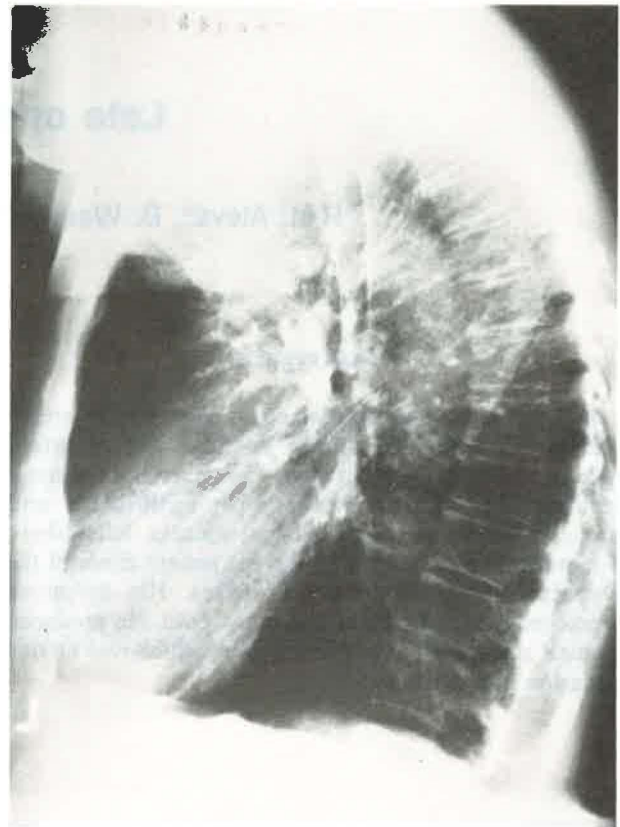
Lateral chest roentgenogram after removal of the tumour
